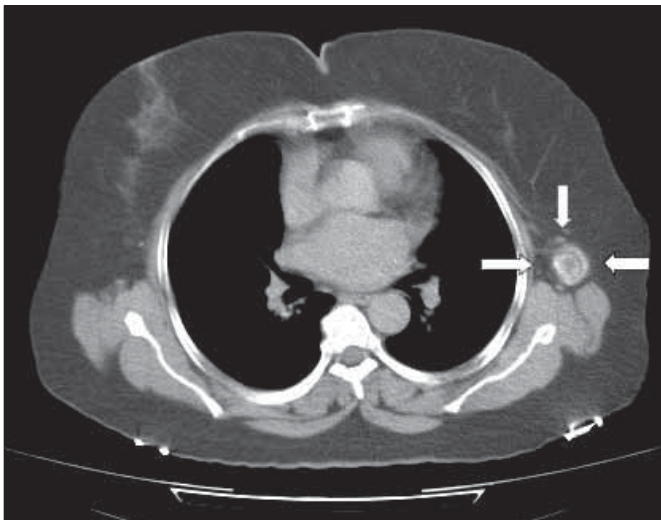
CT image shows a lobular calcified cystic 6x4x3 cm mass in left axillary region
